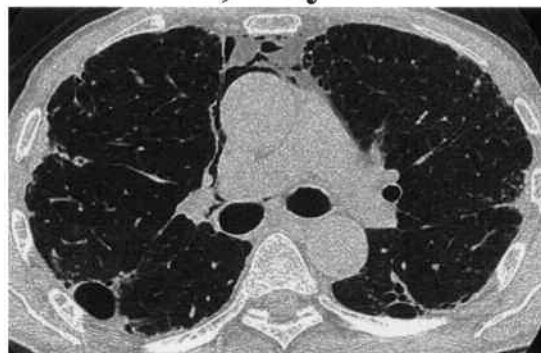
Time course of changes in chest HRCT findings. Chest HRCT on admission revealed an infiltrative shadow and ground-glass opacities in bilateral peripheral lung fields and honeycomb-like cysts on the dorsal side of both lower lung fields (1a). Chest HRCT 6 days after starting azathioprine (AZA) showed an infiltrative shadow and surrounding ground-glass opacities in subpleural regions of the left upper and right upper and middle lobes (1b). After discontinuation of AZA, pulmonary infiltrative shadow and ground-glass opacities disappeared (1c).
